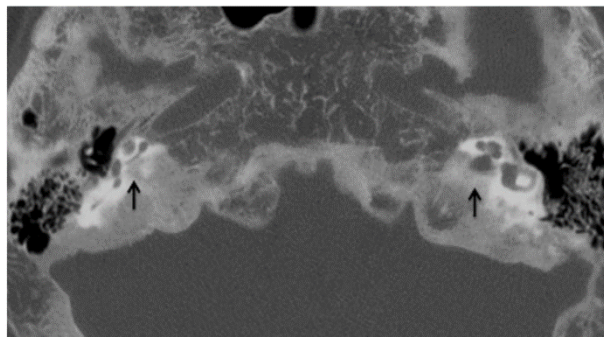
Axial HRCT of the skull base in an adult patient with known Paget's disease. The hypodense appearance of bilateral otic capsules (*arrows*) may mimic otosclerosis; however the diffuse skull base involvement indicates the true pathology
